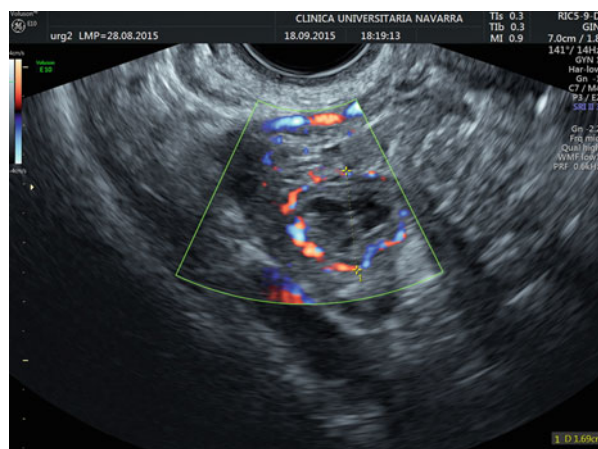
Transvaginal colour Doppler ultrasound showing perifollicular flow
